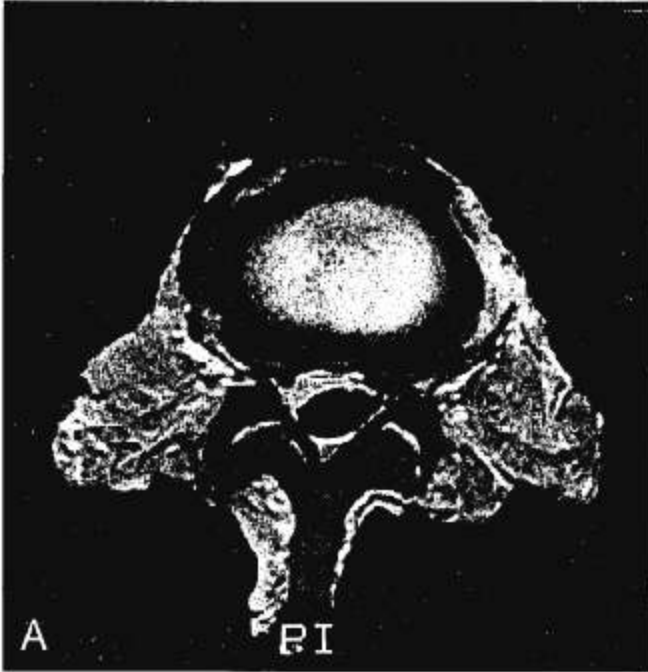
A, Segment 12. Preload axial T1-weighted image. B, Postload. Note loss of smooth contours of outer annular layers with separation of fibers. C, Gross examination. Note changes in morphology of outer annulus with separation of more peripheral layers.
